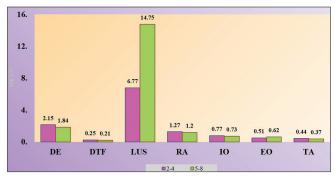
SOFA score compared with different ultrasound methods. (DE: diaphragmatic excursion, DTF: diaphragmatic thickness fraction, LUS: lung ultrasound score, RA: rectus abdominis, IO: internal oblique, EO: external oblique, TA: transversus abdominis)
